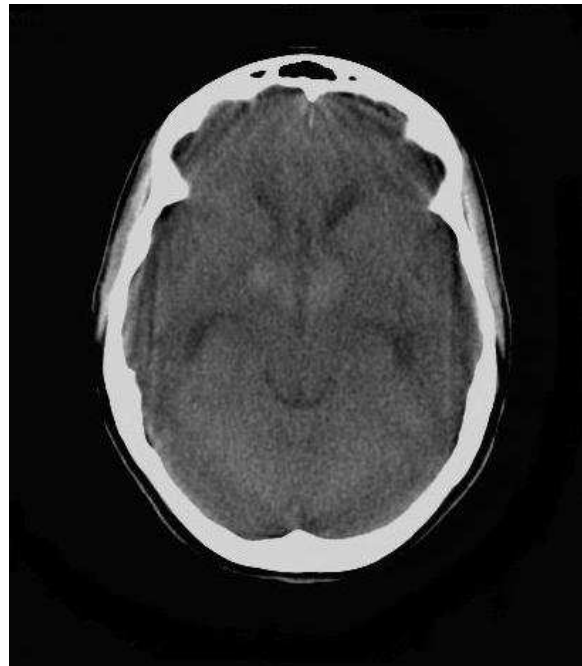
Axial non enhanced CT (NECT) scan of brain (KV: 120, MAS: 60) of a 22-year-old woman with intrinsic third ventricular craniopharyngioma
